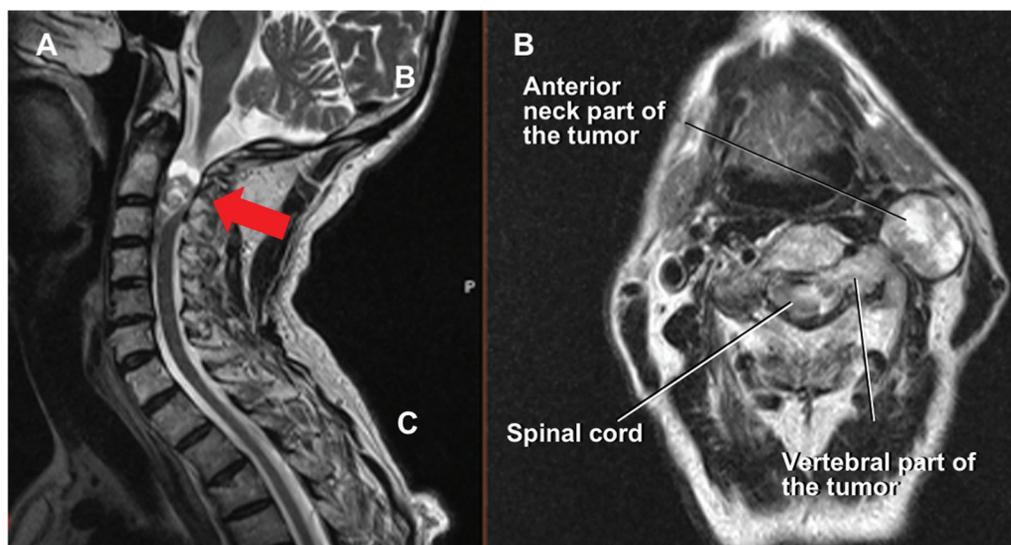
Preoperative magnetic resonance images (MRIs): T2-weighted MRI in sagittal (A) and axial planes (B) and at the level of C3 corpus shows the tumor. (A; arrow)
